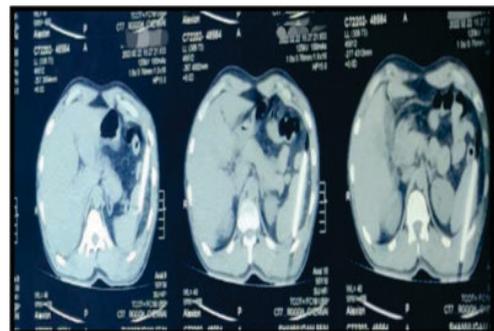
Computed tomography scan of abdomen showing foreign body present intraabdominally, supposedly traversing the spleen.
